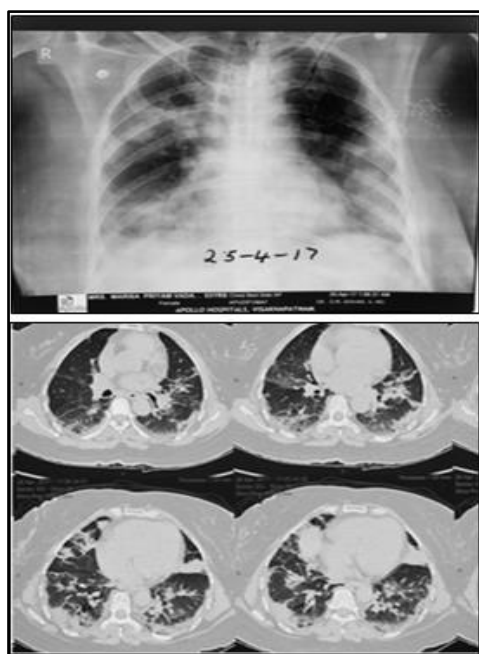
Typical Radiologic and CT Distribution of Opacities with Basal Pleural-Based Predominance
